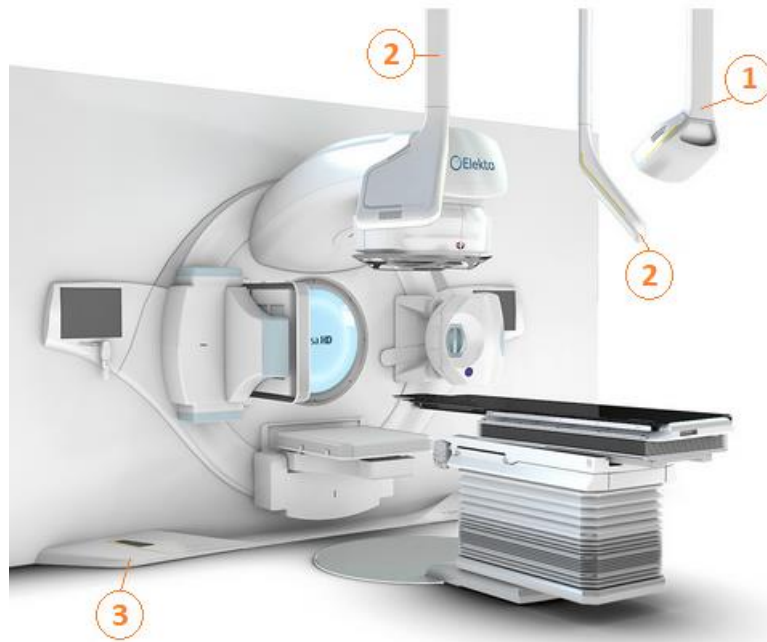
Design of the EXT-D system, integrated with an Elekta Versa HD linac: 1) thermal camera, 2) flat panel detectors, 3) in-floor cover containing the X-ray tubes, one on either side of the linac [89]. Figure reproduced with permission by Brainlab AG.
